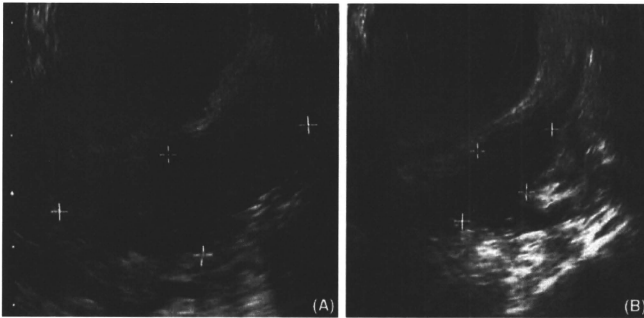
Ultrasonographic images of rectosigmoid endometriotic lesions in Case 2 (A) before and (B) after 20-months of treatment. Magnifications of the two pictures are the same.
